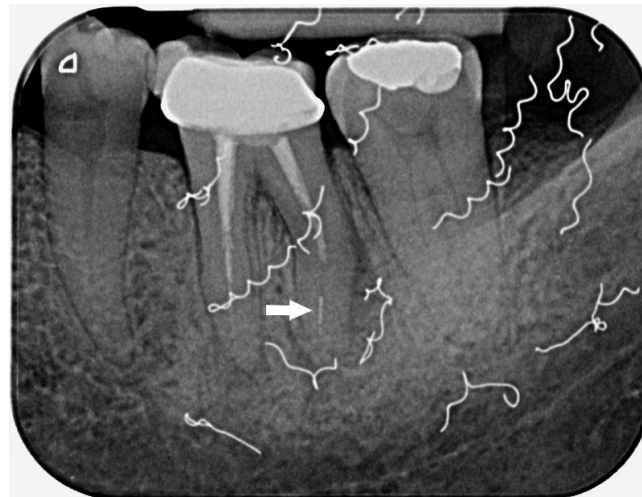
Peri-apical radiograph of tooth 36 showing thread-like springy radio-opaque filaments having the appearance of strewn party streamers. The short filling and the fractured instrument tip in the distal root can also be seen (white arrow)
